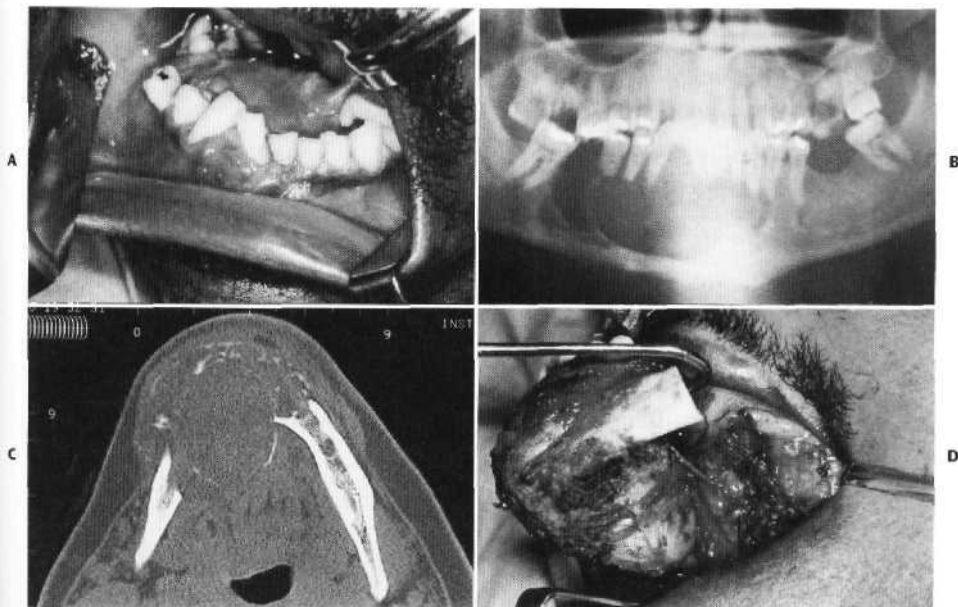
Use of the combination of allogeneic and autogenous bone grafts to reconstruct mandible after resection for ameloblastoma. A, Large expansile lesion of mandibular body and symphysis. B, Panoramic radiograph of lesion. C, Axial computed tomogram showing size of lesion. D, Resection of lesion via a transoral approach.
